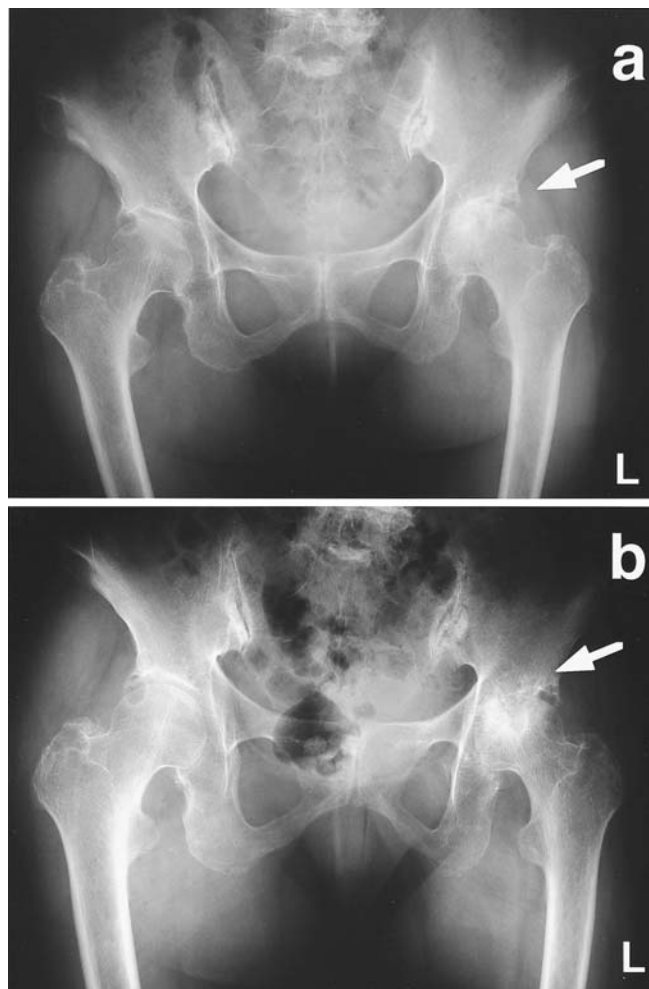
Radiographs of both hips. a X-ray examination of the left hip joint in September 2000, showing closing of the joint space in the weight-bearing area, a radiolucent area in the femoral head, and bone atrophy. b Preoperative radiograph 4 months later, showing medial deviation of the left femoral head and extension of the radiolucent area, resulting in progressive joint destruction
